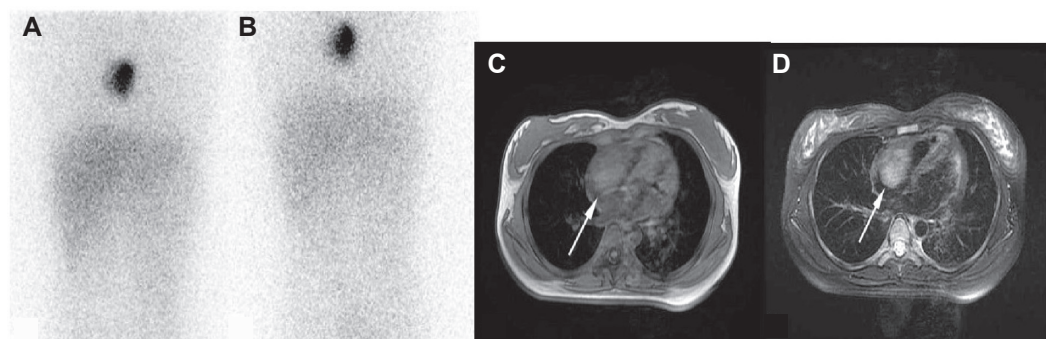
^{123}I -MIBG scintigraphy in a 16-year-old girl with cardiac pheochromocytoma. Planar anterior images at 24 hours (A) and 48 hours (B) after injection. The result of radionuclide scan is concordant with MRI (C and D), which shows the mass locating in right atrium. Copyright © 2006. Provided by Ruijin Hospital, Shanghai, China. Published in *Chin J Nucl Med.* 2008; 28(4)
